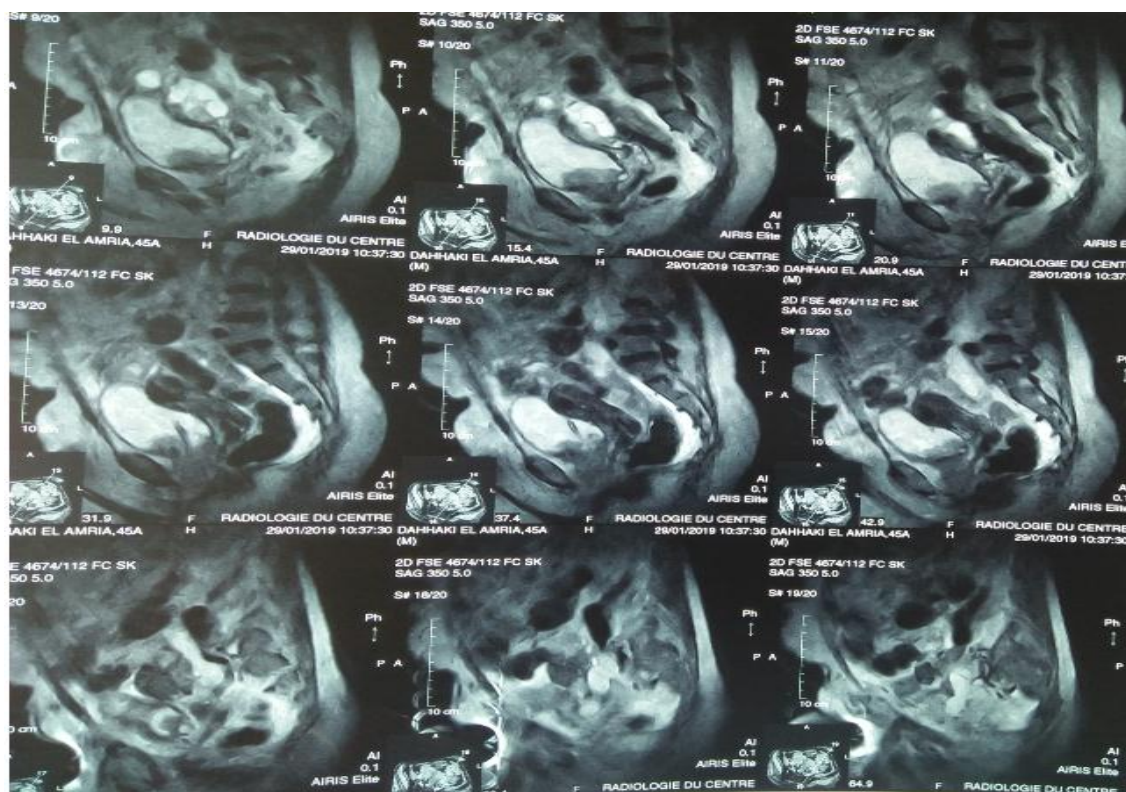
MRI pelvis showing a invasive urethral mass 6.5 × 6 cm with heterogeneous enhancement in bladder neck and urethra concerning for urethral neoplasm.
